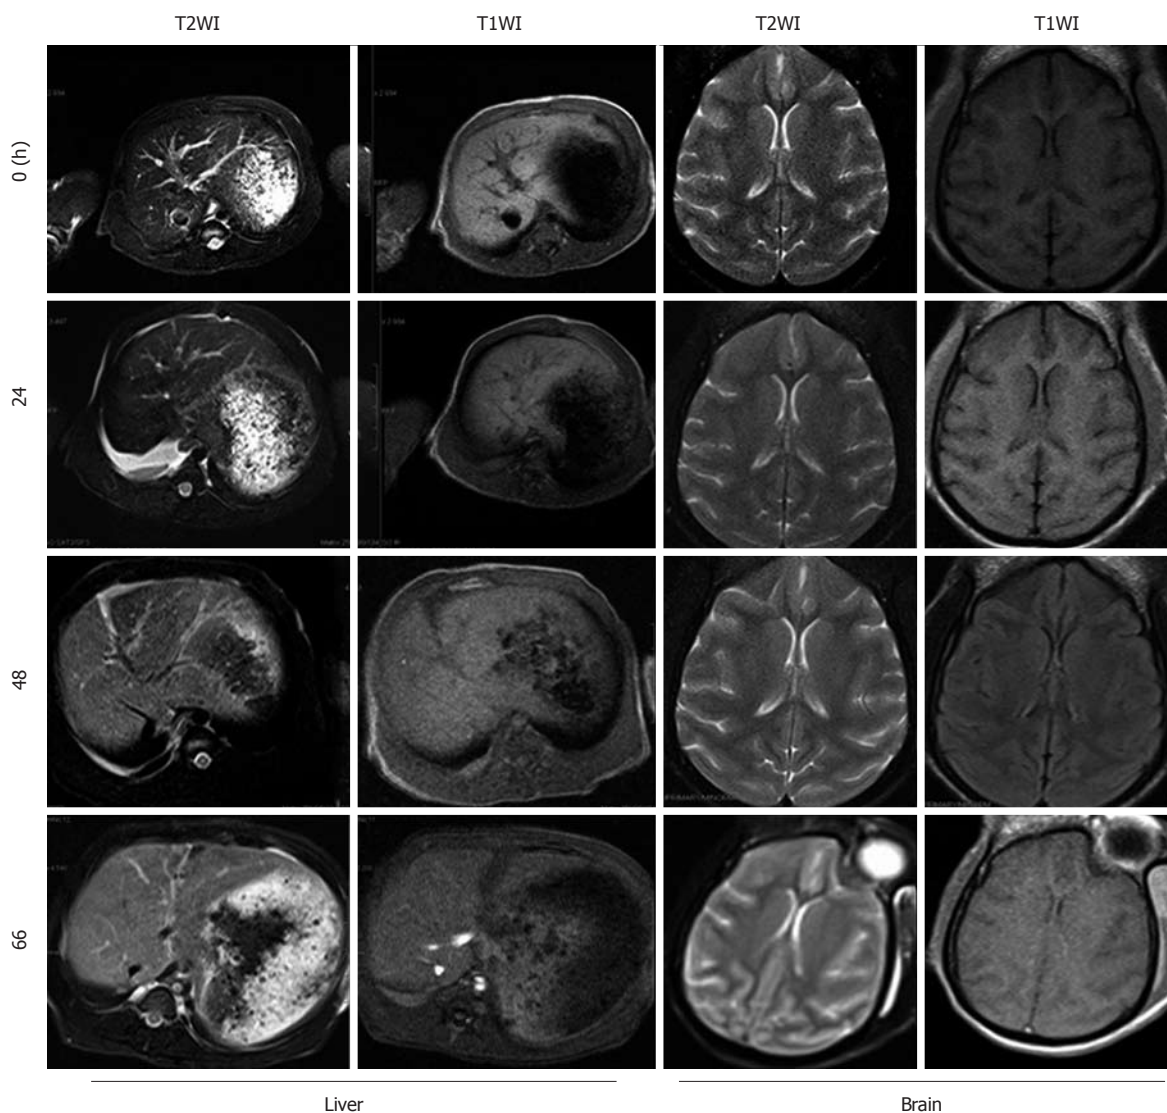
Magnetic resonance imaging of the liver and brain of *Macaca mulatta* model at different times. T2WI: T2-weighted imaging; T1WI: T1-weighted imaging.
